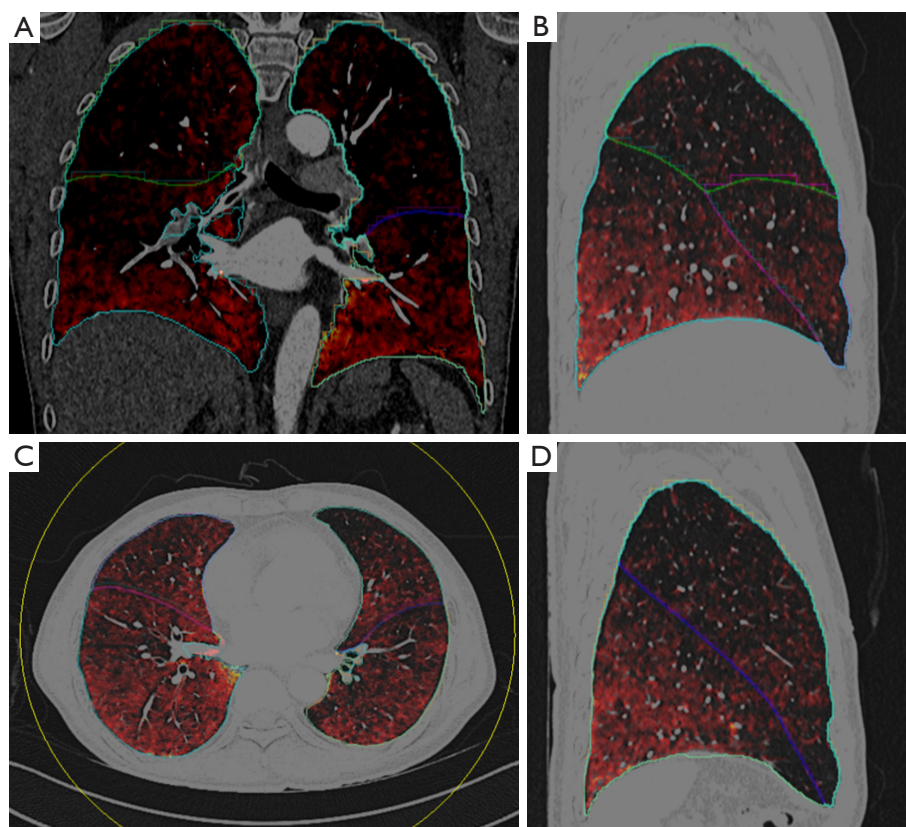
Semi-automatic lung lobe segmentation using dual-energy computed tomography imaging. (A) Coronal view; (B) sagittal view, right lung; (C) axial view; (D) sagittal view, left lung.
